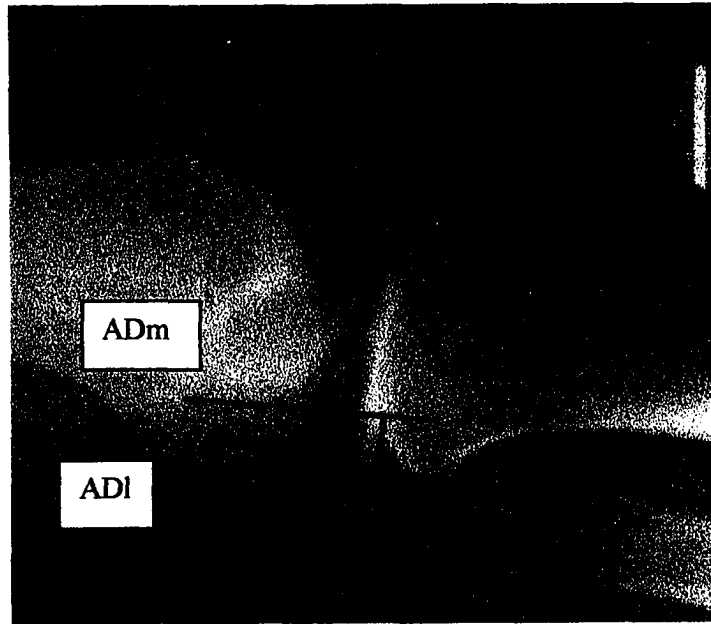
Radiographic assessment. Lateral radiograph measuring anterior displacement medially (ADm) and anterior displacement laterally (ADI) with applied stress.
